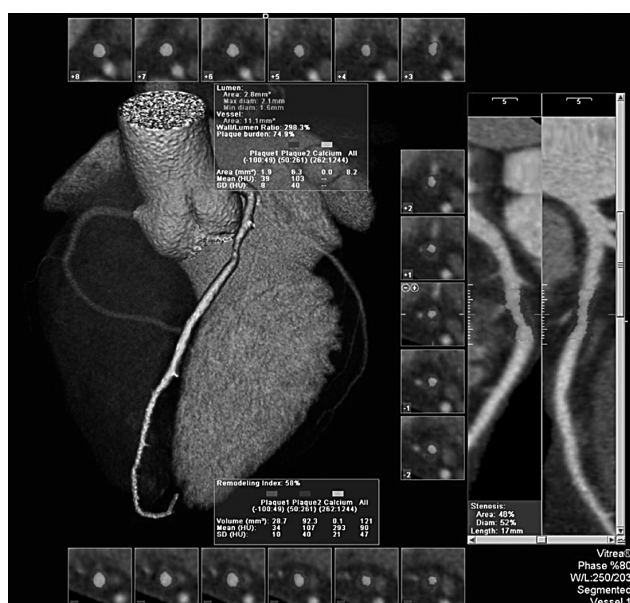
3D vessel probe of the Left Main and left anterior descending (LAD) coronary artery from CT angiography. Curved Multi-planar Reconstruction (MPR) images are automatically rendered and quantify this LAD lesion at 48% diameter stenosis. SUREPlaque software is used to determine plaque burden and a vessel remodeling index at this lesion. Images courtesy of Courtesy of Toshiba America Medical Systems and Vital Images SUREPlaque and University of California Irvine, Cardiac CT Center.
